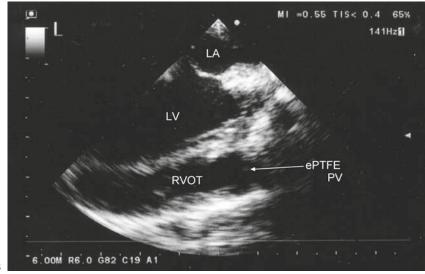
Transesophageal echocardiography (TEE) after the Ross procedure. A Trivial autograft regurgitation during diastole; B no right ventricular outflow tract (*RVOT*) obstruction. *LVOT*, Left ventricular outflow tract; *ePTFE PV*, expanded polytetrafluoroethylene pulmonary valve
